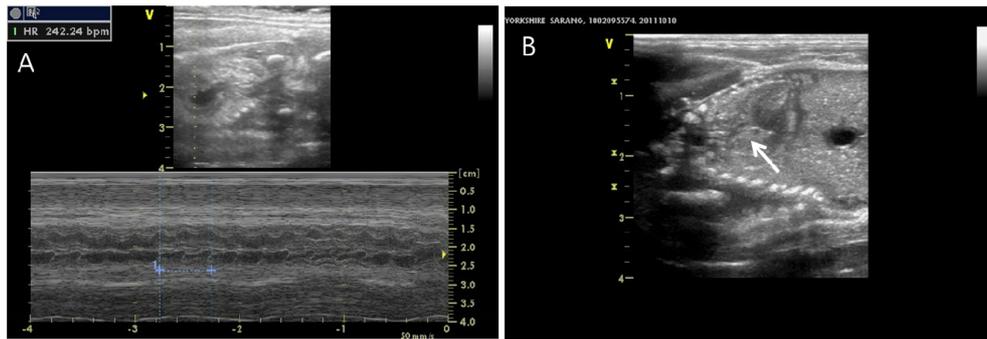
Abdominal ultrasound of this case. A: Taken at 45 days after mating. There was normal heart beating suggesting those two fetuses were survived. B: Taken at 55 days after mating. There was no heart beating suggesting those two fetuses were dead.
